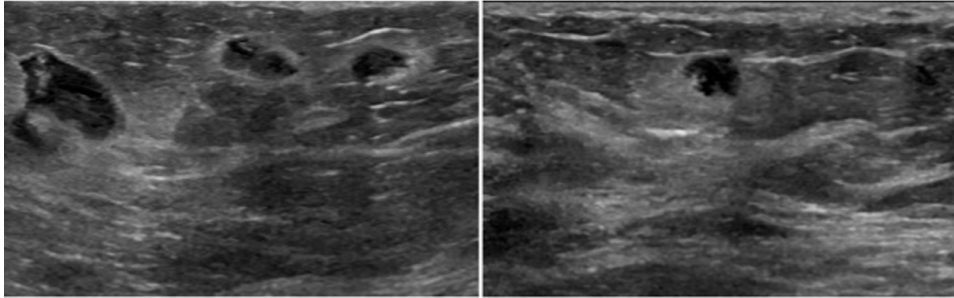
Gray scale ultrasound images demonstrate multiple irregular, hypoechoic masses with angular margins in the right breast (left image) and a similar-appearing mass in the left breast (right image). These correlate with the masses noted on mammogram.
